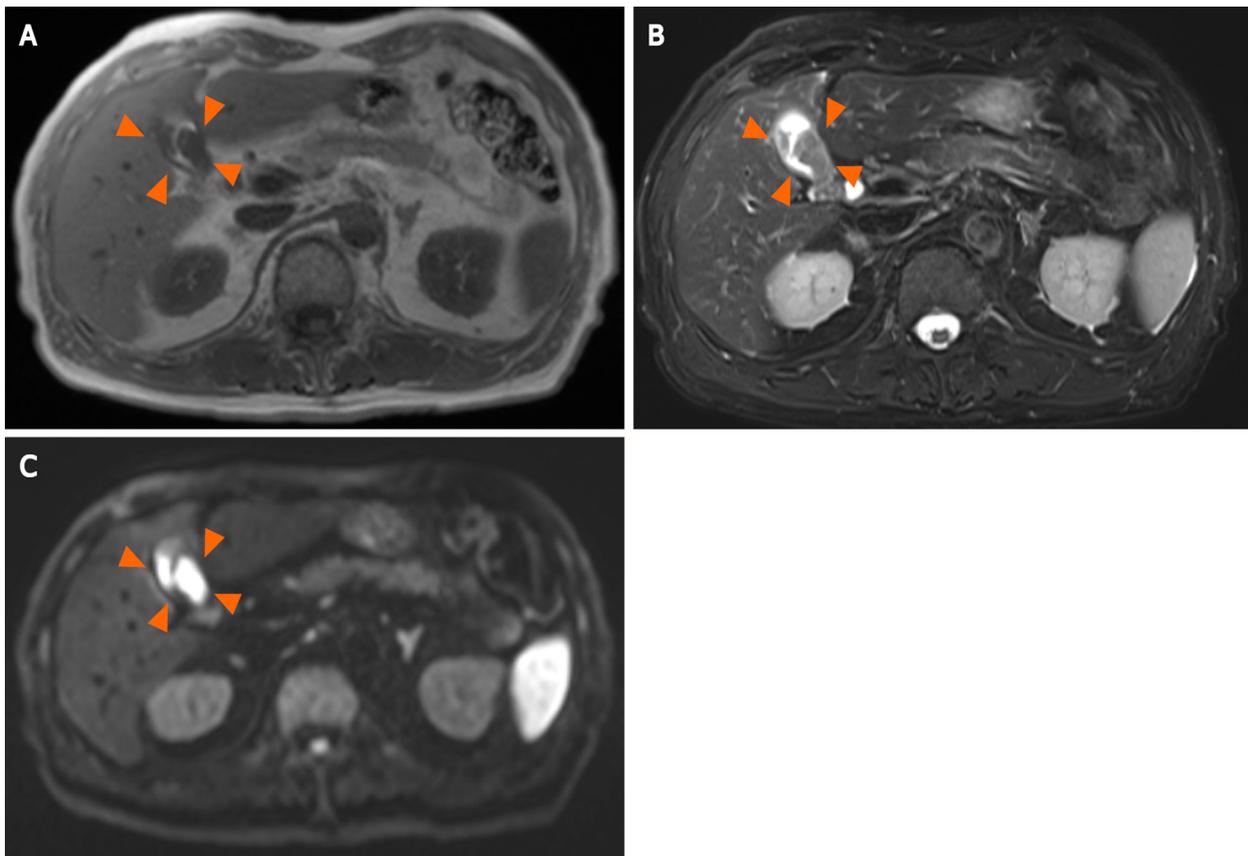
Magnetic resonance imaging reveals a hypointense tumor signal. A: T1-weighted imaging (arrowheads); B: A hyperintense signal on T2-weighted imaging (arrowheads); C: Diffusion-weighted imaging (arrowheads).
